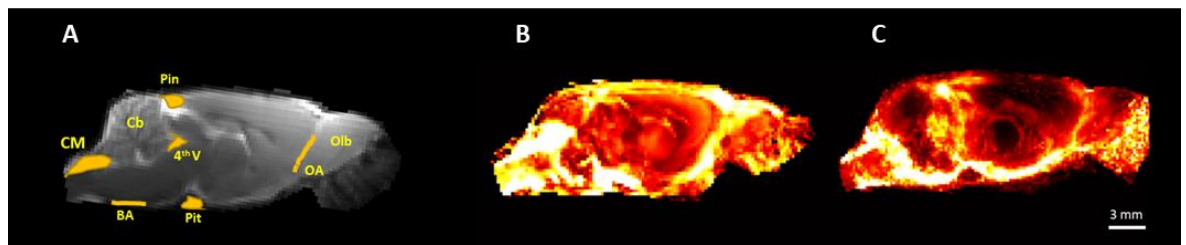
3D visualization constructed images representing perivascular influx of $H_2^{17}O$ and Gd-DTPA. (A) 2D T_2 weighted MRI with the anatomical structures displayed. (B) 3D visualization constructed from T_2 weighted images demonstrates $H_2^{17}O$ distribution along perivascular spaces and in all brain regions. (C) 3D visualization constructed from T_1 weighted images demonstrates Gd-DTPA distribution along perivascular spaces with limited penetration into the brain.
